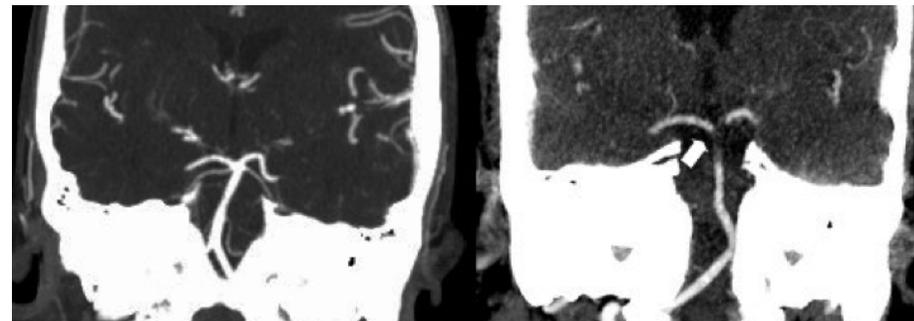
Coronal CTA showing normal terminal basilar artery anatomy (left) and acute occlusion (right, arrow).
